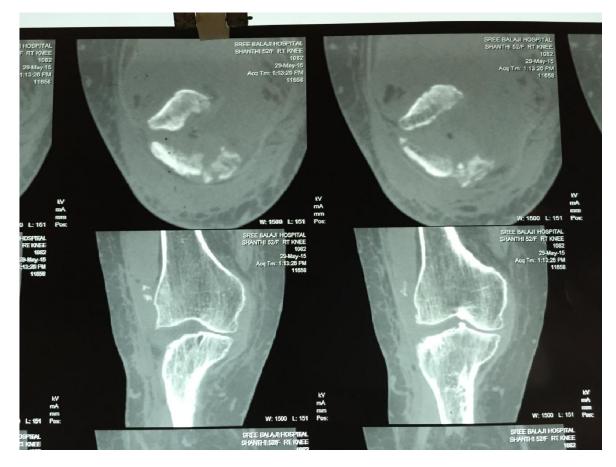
CT Scan of the knee showing the same
